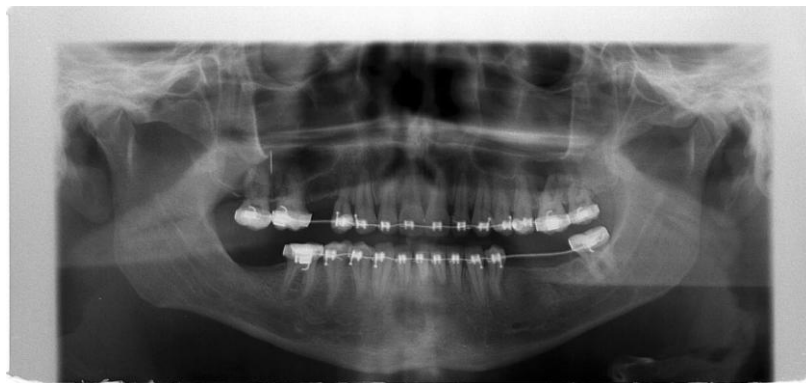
Roentgen panoramic image before the treatment
